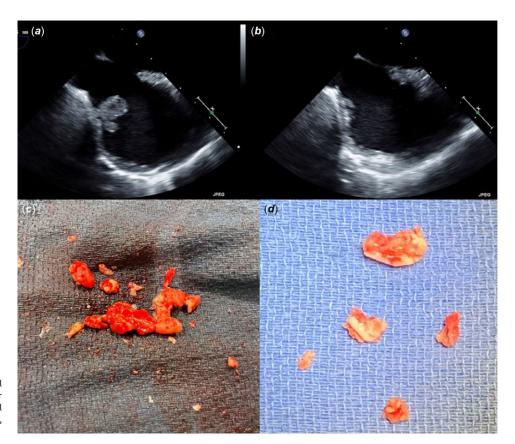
(a and b) Transoesophageal echocardiogram (TEE) images before and after thrombus removal in Case 1 with no residual thrombus. (c) Removed thrombus from Case 1, (d) removed tumour from Case 3.
